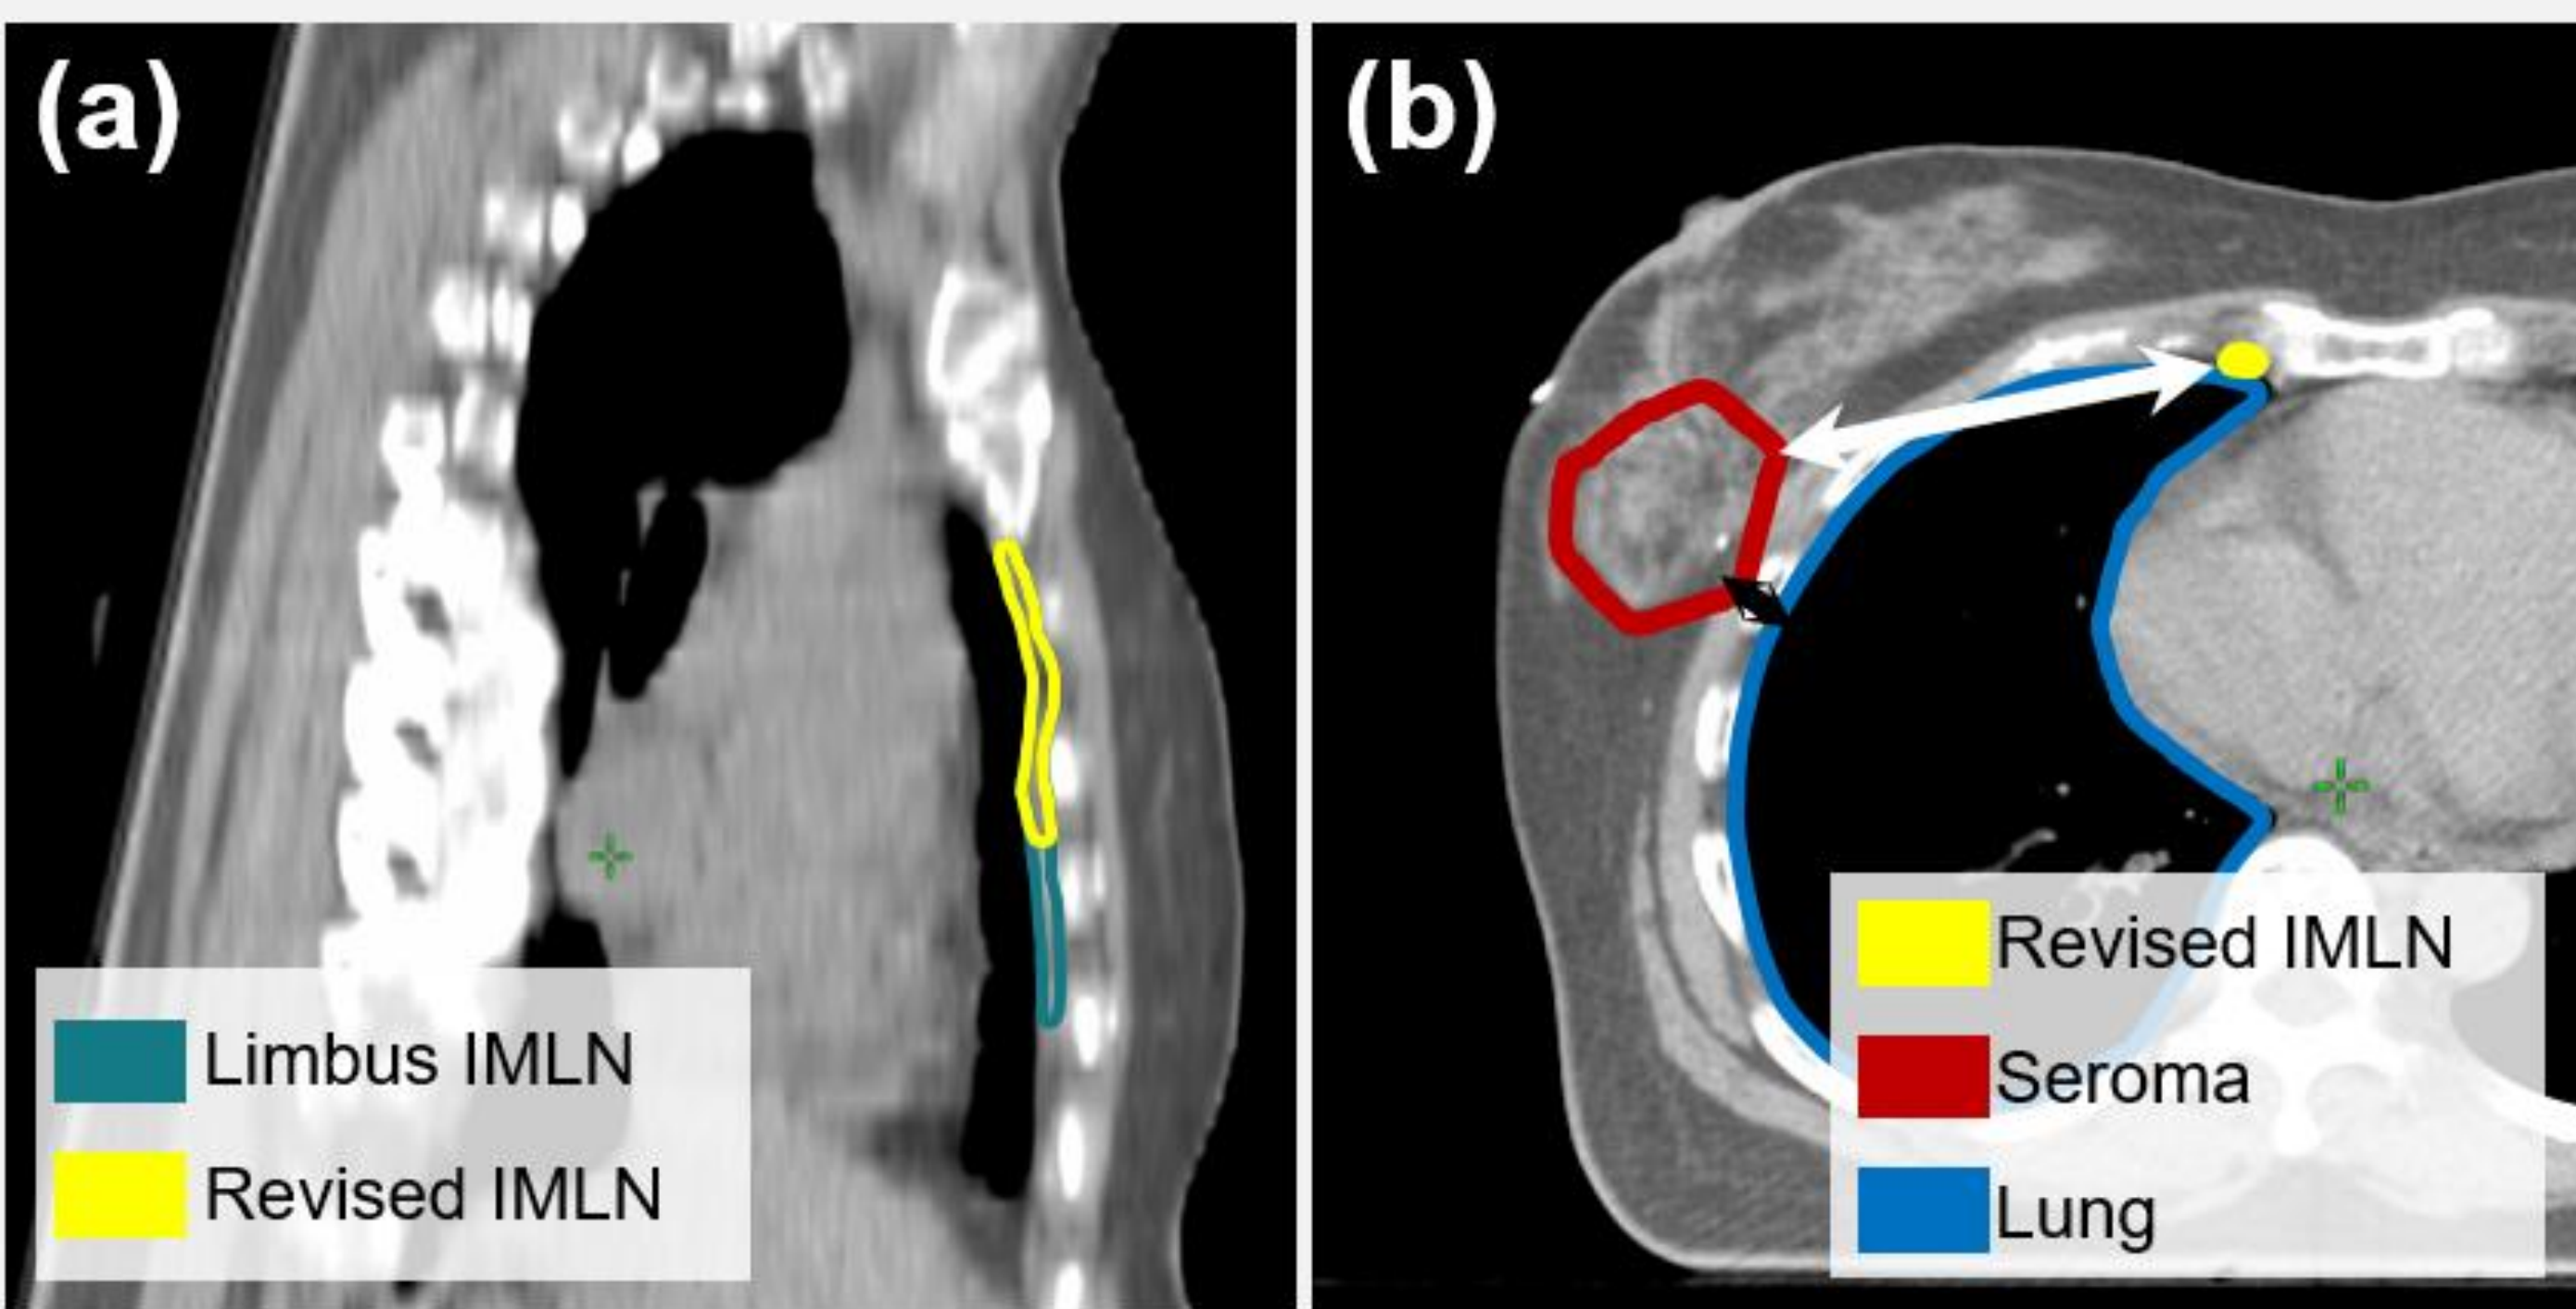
(a) Sagittal CT slice showing the Limbus-generated (teal) and revised IMLN (yellow) contours. (b) Axial CT slice showing the minimum seroma-to-IMLN (white arrow) and seroma-to-lung (black arrow) distances, calculated in 3D using the bidirectional local distance.⁶ Seroma-to-lung distances were used as a surrogate for tumour distance from the deep mammary plexus that drains to the IMLNs.
